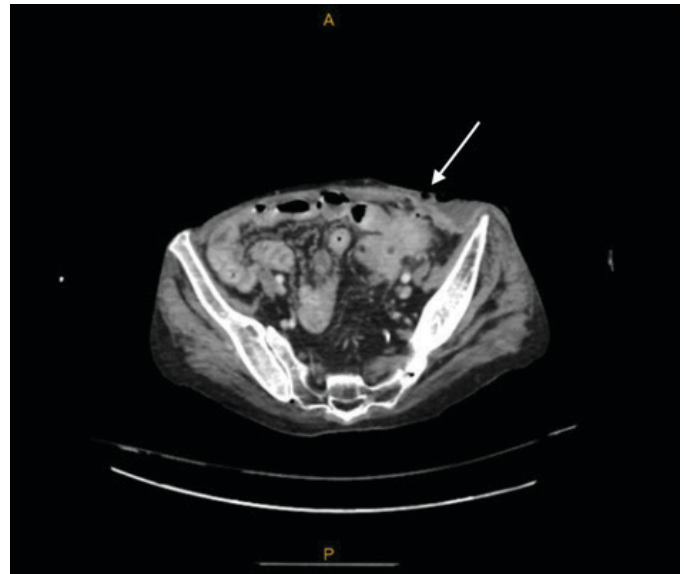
Abdominal computed tomography (CT) scan with abnormal mucosal thickening with thin linear fistula (see arrow) connecting to superficial abdominal wall collection, suggesting enterocutaneous fistula and anterior abdominal collection.
